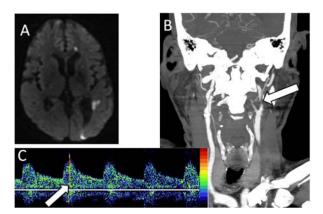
Diffusion-weighted MRI (A) shows ischemic infarcts in left internal carotid artery territory with high-grade stenosis on CT angiography (B). Transcranial Doppler monitoring showed spontaneous microembolic signals (C).
